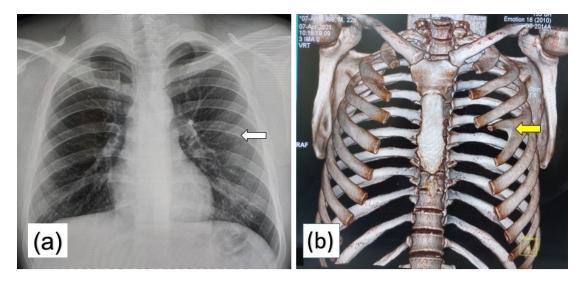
(a) Chest X ray PA view showing bifid left 4th rib with solid arrow. (b) CT chest showing bifid left 4th rib, marked with yellow arrow.
